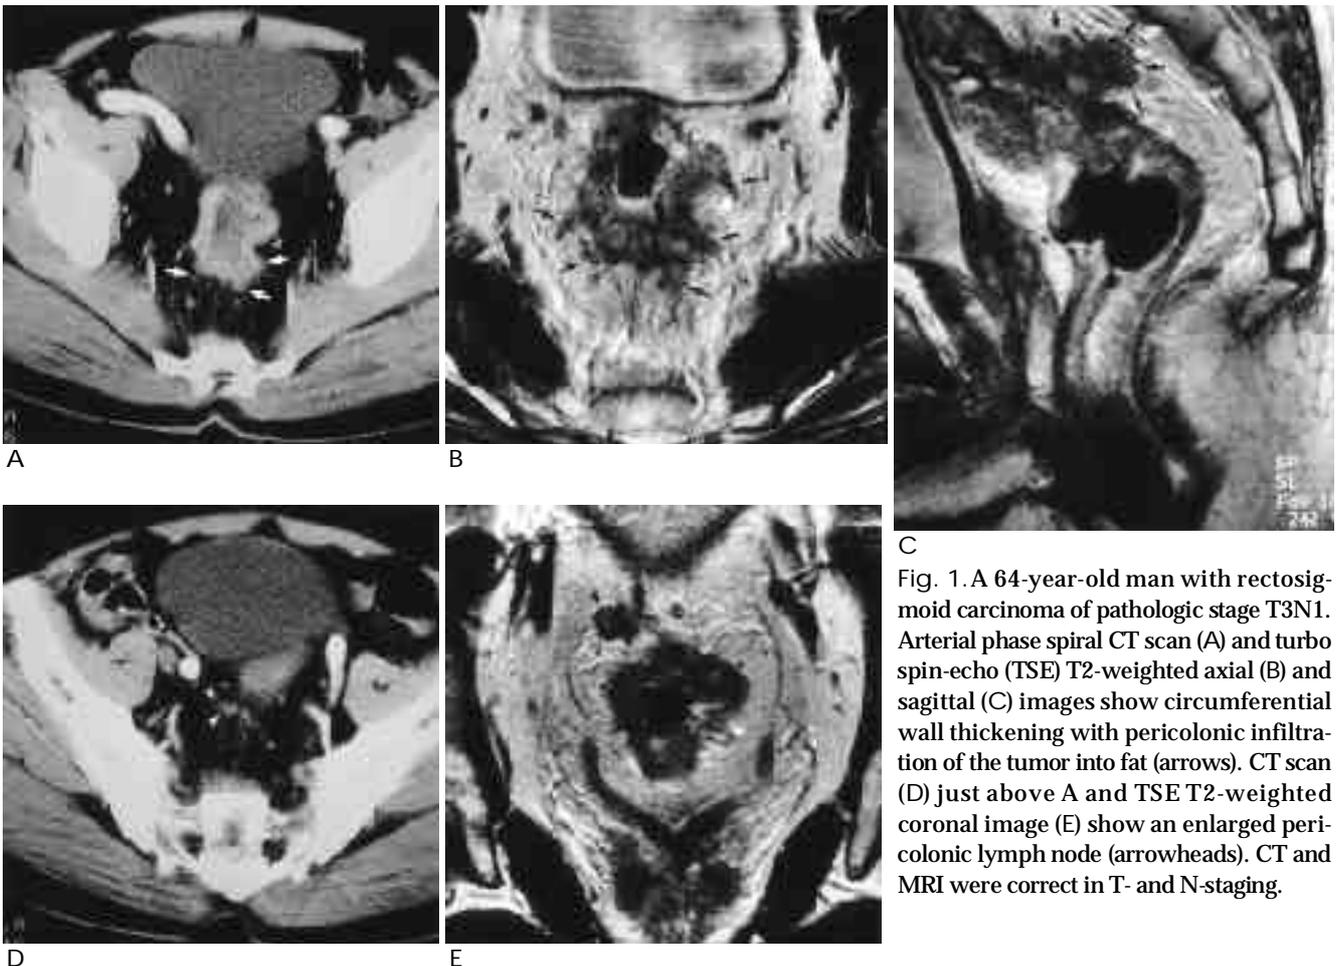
A 64-year-old man with rectosigmoid carcinoma of pathologic stage T3N1. Arterial phase spiral CT scan (A) and turbo spin-echo (TSE) T2-weighted axial (B) and sagittal (C) images show circumferential wall thickening with pericolic infiltration of the tumor into fat (arrows). CT scan (D) just above A and TSE T2-weighted coronal image (E) show an enlarged pericolic lymph node (arrowheads). CT and MRI were correct in T- and N-staging.
